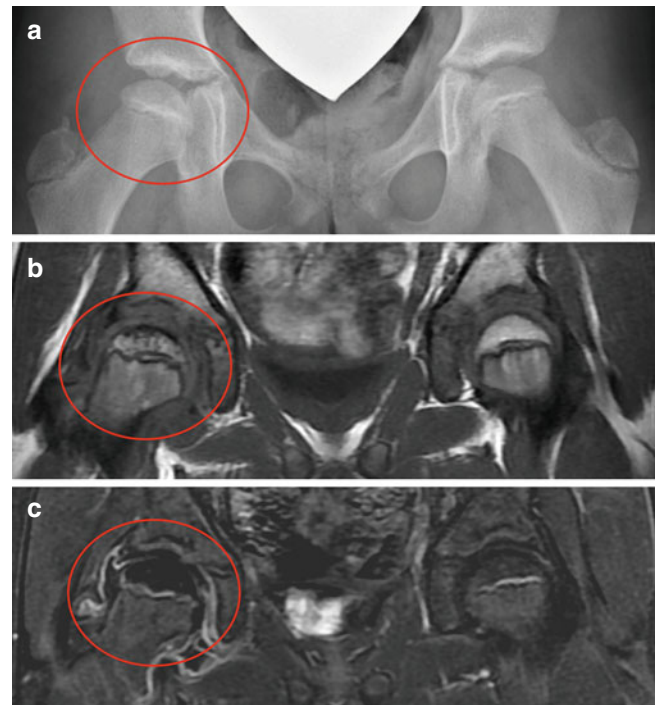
An 11-year-old female with a history of intermittent right hip pain for 2 months prior to the following AP pelvis radiograph (a) and MRI showing non-contrast coronal T1 FSE image (b) and corresponding contrast-enhanced subtraction image (c). (a) AP radiograph shows right femoral head (circle) is in the initial stage of LCPD (stage I) with slightly smaller ossific nucleus and increased radiodensity without any fragmentation. (b) Non-contrast T1 image shows decreased signal in the superior region of the femoral head with spotty areas of decreased signal within the epiphysis. Percent head involvement measured by four observers was 28, 33, 42, and 67 %, showing some interobserver variability. (c) Contrast-enhanced subtraction image shows that most of the epiphysis is lacking contrast enhancement (i.e., hypoperfusion). Percent head involvement measured by four observers was 77, 78, 80, and 97 %, showing a larger extent of involvement than depicted by non-contrast imaging. Better interobserver agreement was observed using contrast imaging (From Kim et al. [49])
